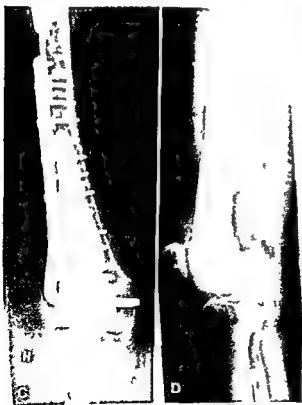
C and D Postoperative radiographs The intramedullary cavity is filled with bone cement The condylar plate has been fixed with screws through the implanted cement
